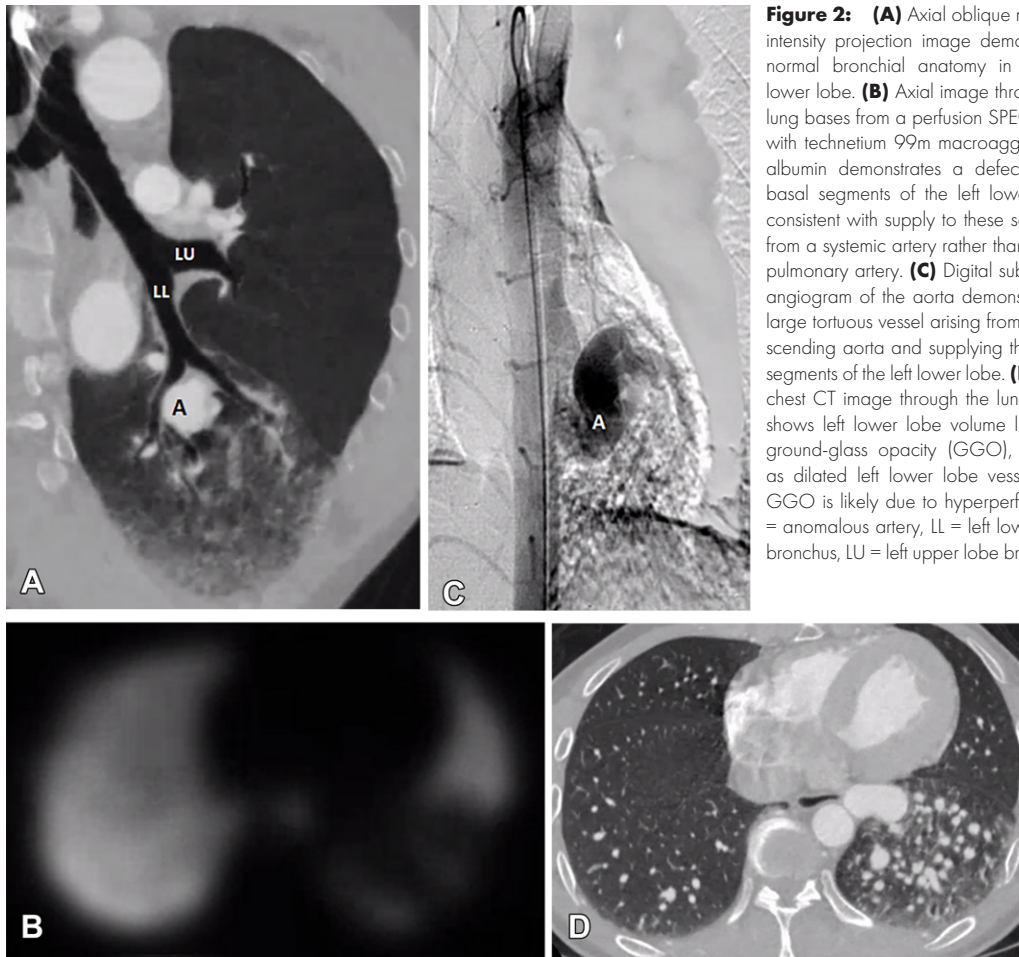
(A) Axial oblique minimum intensity projection image demonstrates normal bronchial anatomy in the left lower lobe. (B) Axial image through the lung bases from a perfusion SPECT scan with technetium 99m macroaggregated albumin demonstrates a defect in the basal segments of the left lower lobe, consistent with supply to these segments from a systemic artery rather than from a pulmonary artery. (C) Digital subtraction angiogram of the aorta demonstrates a large tortuous vessel arising from the descending aorta and supplying the basal segments of the left lower lobe. (D) Axial chest CT image through the lung bases shows left lower lobe volume loss and ground-glass opacity (GGO), as well as dilated left lower lobe vessels. The GGO is likely due to hyperperfusion. A = anomalous artery, LL = left lower lobe bronchus, LU = left upper lobe bronchus.
